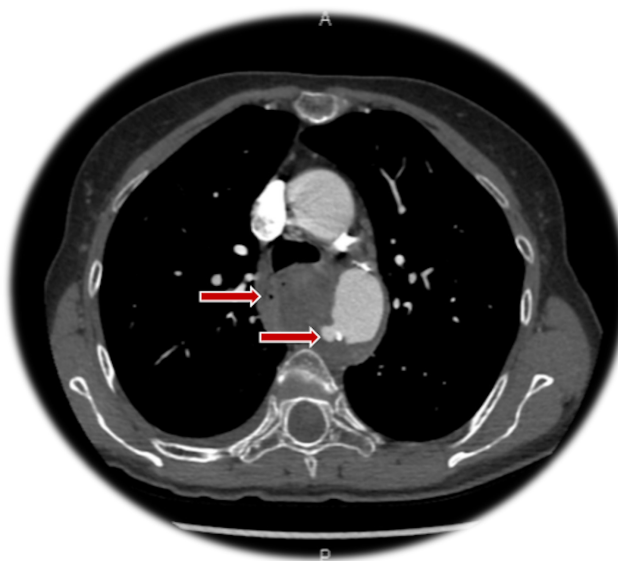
The CTA image shows the pseudoaneurysm at the aortic arch – descending aortic border, arrows indicate thoracic aortic contrast leakage and mediastinal air leakage
